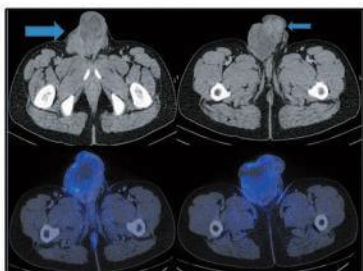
A, B, C and D: Axial CT and PET CT images of inguinoscrotal region reveal a large, ill-defined heterogeneously enhancing mass lesion in the scrotal sac on right side (large blue arrow), displacing the left testis laterally (small blue arrow), extending proximally along the spermatic cord up to the inguinal region. Right testis is not seen separately from the lesion. The lesion shows increased FDG uptake on PET CT scan.
